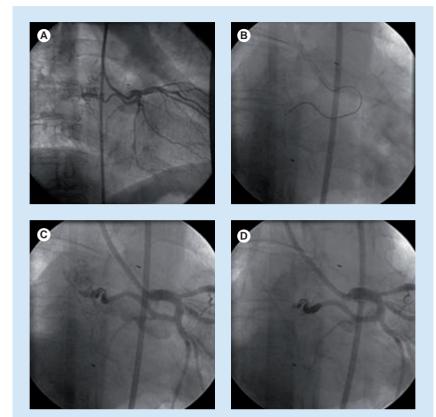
Coil embolization of coronary artery fistulas. (A) Coronary artery fistula from circumflex artery to pulmonary artery causing ischemia shown by myocardial perfusion scintigraphy. (B) Coronary artery fistula was crossed with a 0.014-inch wire. (C) Multiple detachable coils were deployed into the fistula. (D) Control angiography revealed no residual flow through the fistula.
